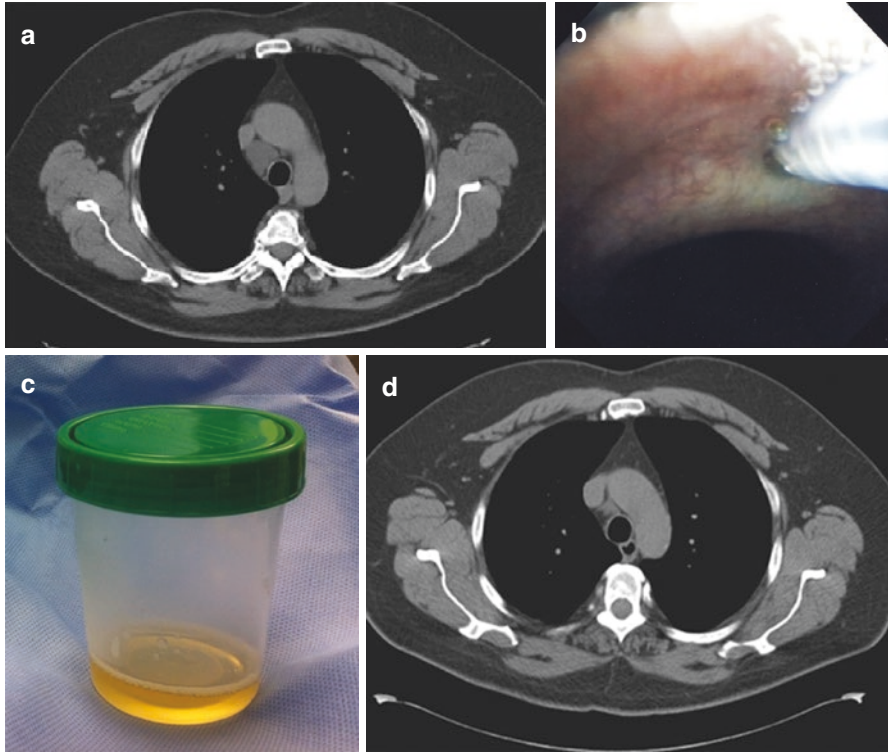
(a–d): Chest CT (a) showing bronchogenic cyst in an asymptomatic patient. Patient initially declined surgery. He underwent a transbronchial needle aspiration (b) that yielded about 20 ml of straw-colored fluid (c). A repeat CT after the procedure showed a significant decrease in size of the cyst. After a few months, patient underwent successful surgery due to re-accumulation of fluid
